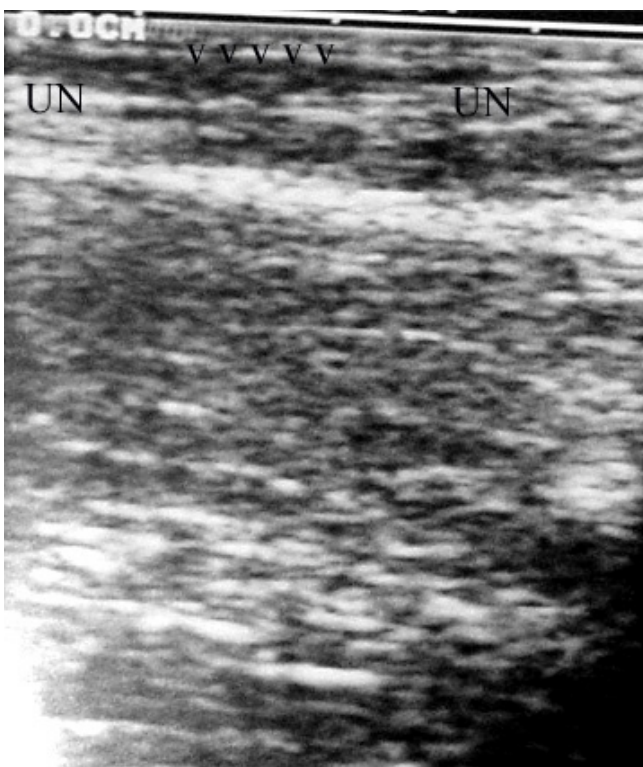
Ultrasonographic neurography shows ulnary nerve and compression site (UN: Ulnary nerve, Arrows show the compression site).
